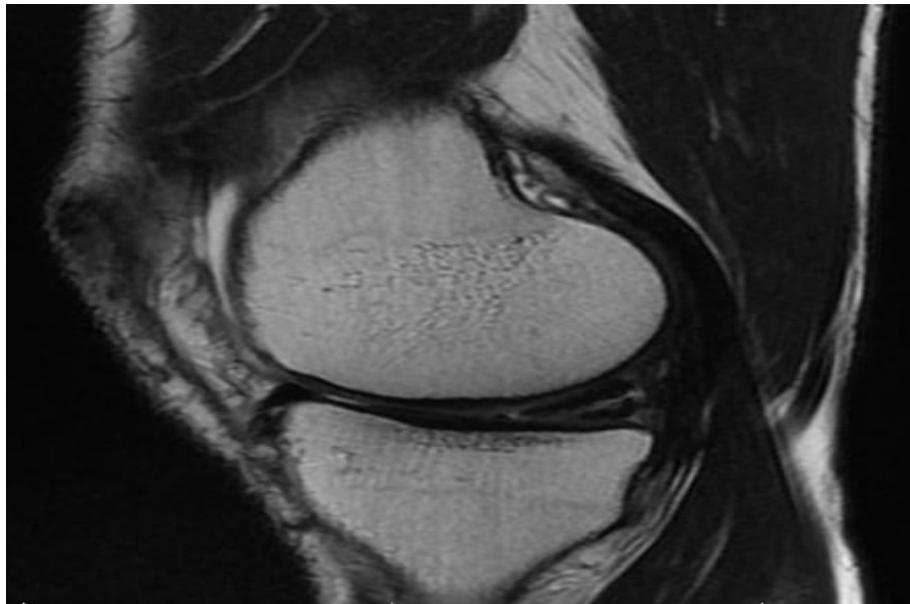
MR image of the knee joint of patient R., 36 years old. Sagittal projection. Combined tear of the posterior medial horn of the meniscus. The shape of the medial meniscus is normal, with a vertical and horizontal hyperintense line in its structure.
